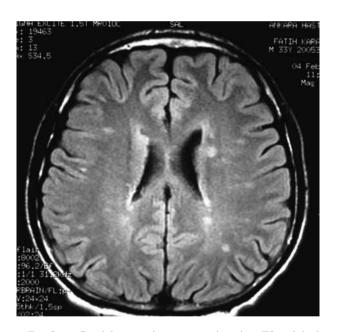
Cranial magnetic resonance imaging. T2 weighed images. Multiple foci of increased signal intensity in the periventricular white matter and cerebellar hemispheres (transvers view).
